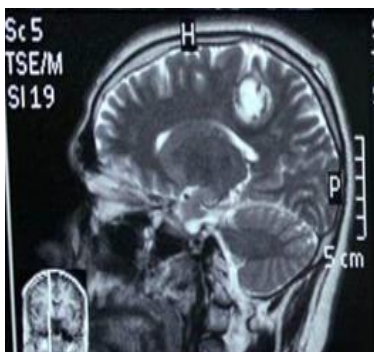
A: Pre-operative sagittal T2-weighted MRI, reveals the location of the cavernoma deep to the precentral gyrus (primary motor cortex).
